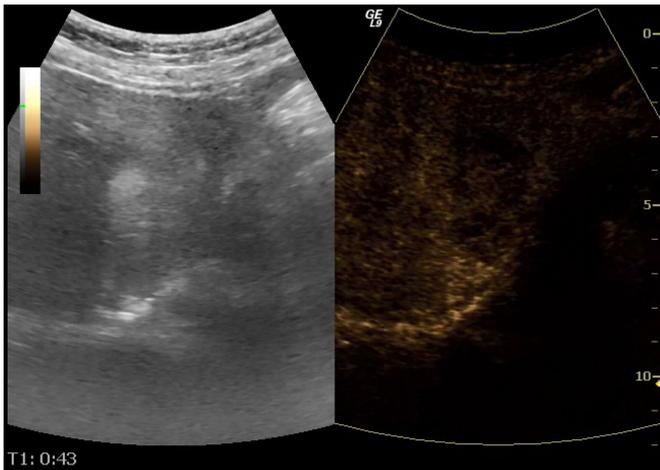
Contrast enhanced ultrasonography view of the liver lesions - arterial phase
